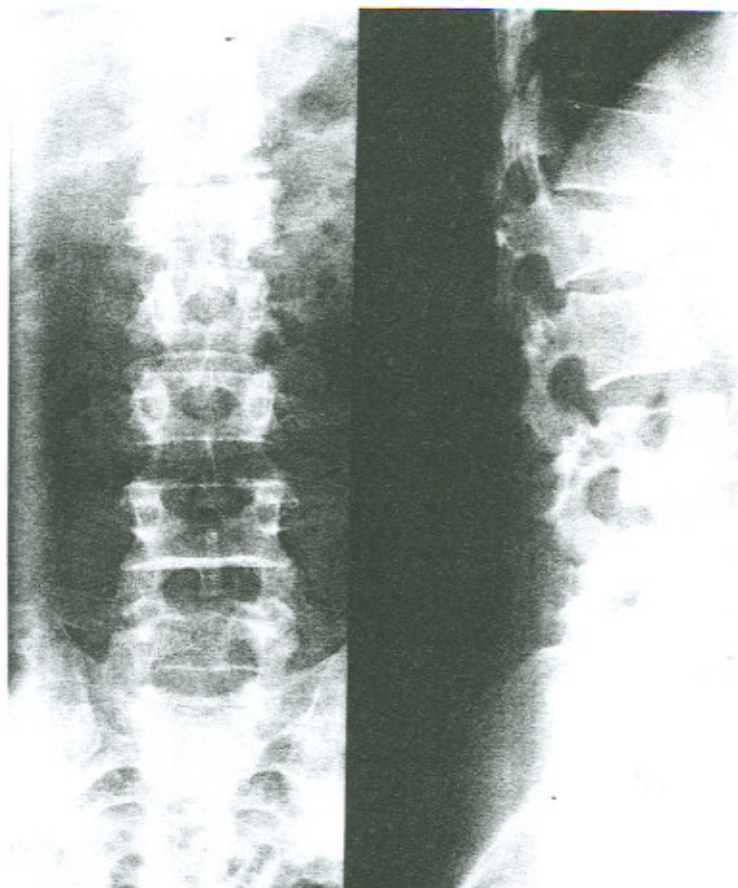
AP and lateral radiographs ordered to include the thoracolumbar junction. Lateral wedging and an increase in the interspinous distance are evident on the AP view. Obvious compression fracture of L1 is noted.
